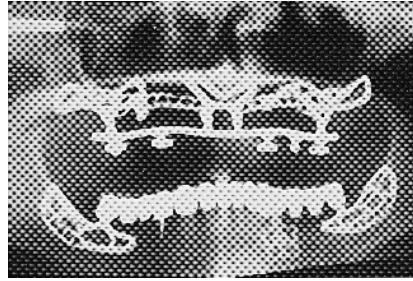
A panoramic X-ray showing the earlier rigid posterior buccal loops.
